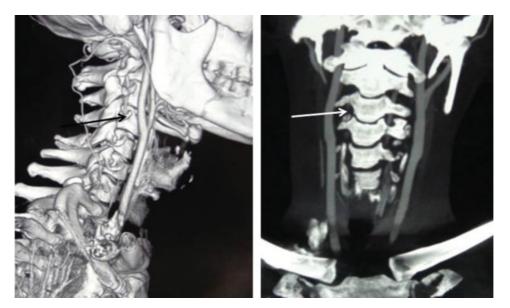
CT angiogram of case 2 shows partial obstruction of the vertebral artery (arrows) secondary to dissection.
